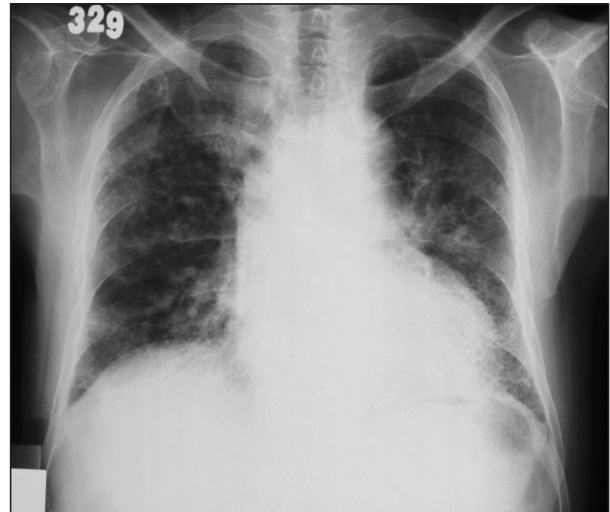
Chest x-ray imaging of the patient; bilateral diffuse reticulonodular infiltrations.
